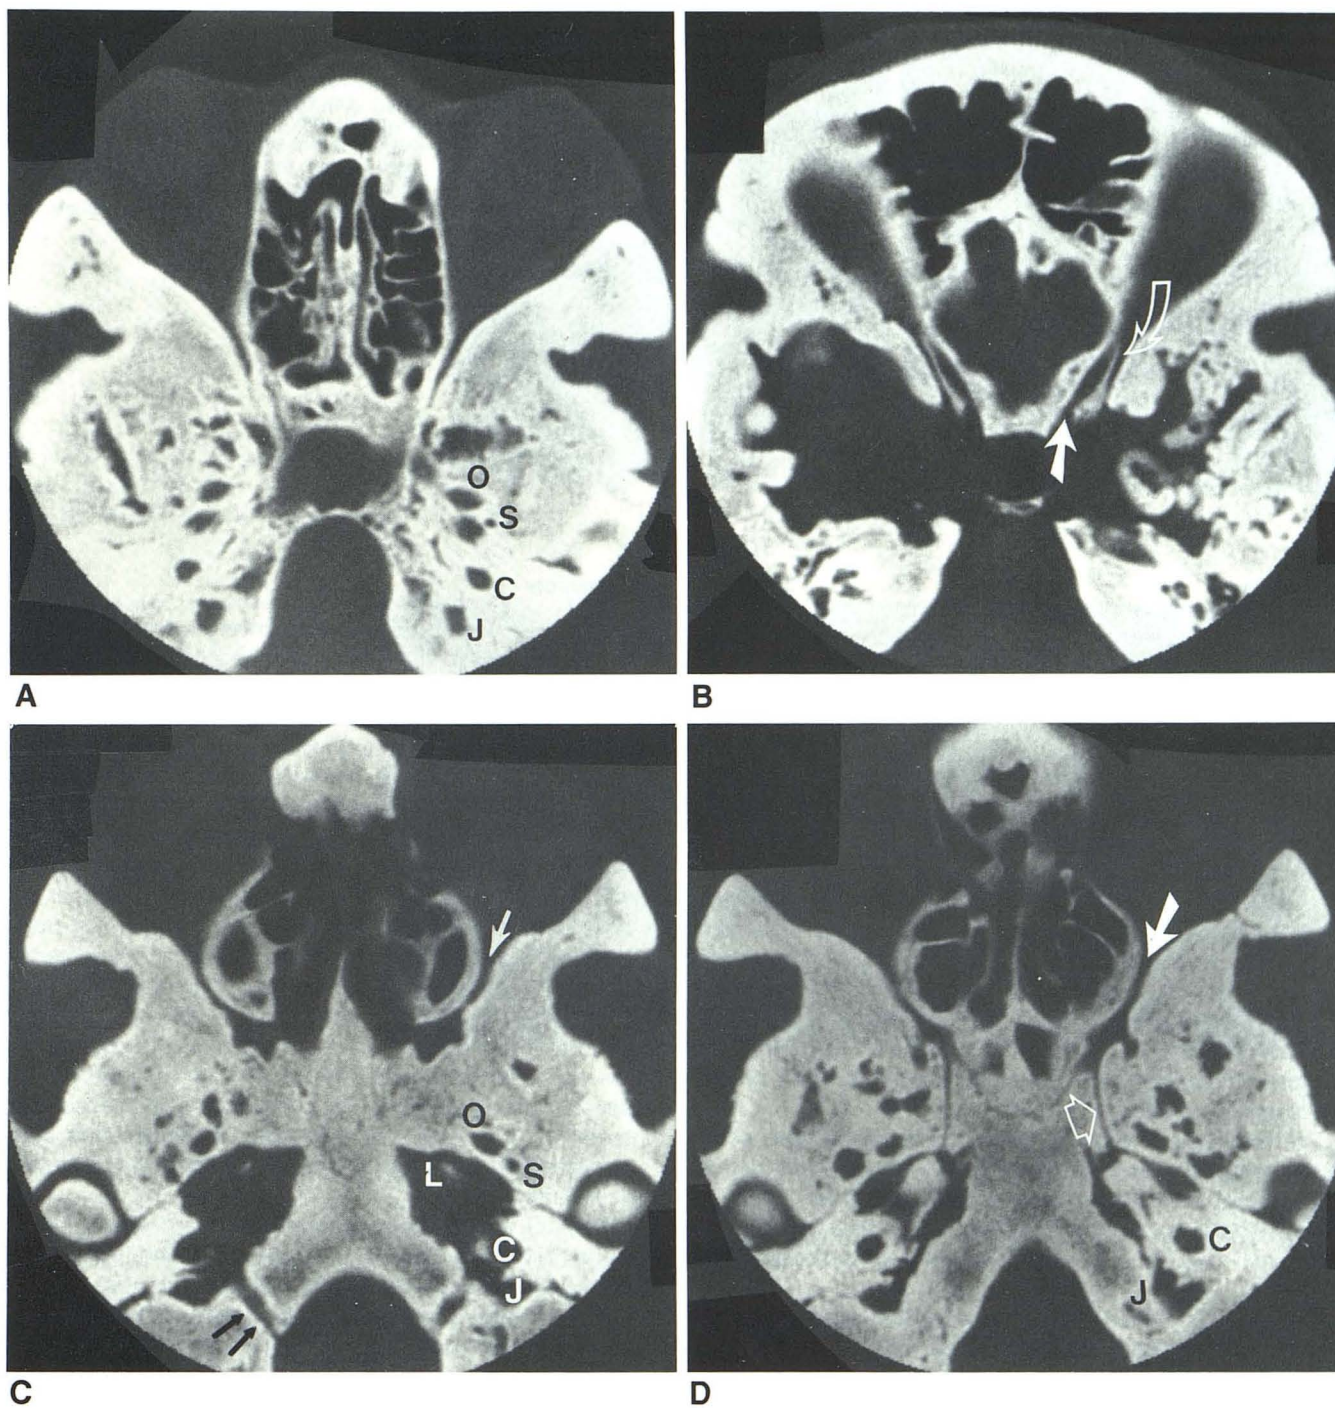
A, Axial CT scan shows thickening of orbital walls and small orbital volume with bilateral proptosis. Ethmoid sinuses are well aerated but walls are thickened. O = foramen ovale, S = spinosum, C = carotid canal, and J = jugular canal. Several pseudofoveae are formed by bony excrescences. B, Axial CT scan shows marked thickening of greater wings of sphenoid bones contributing to narrowing of superior orbital fissures (*open arrow*) that are
